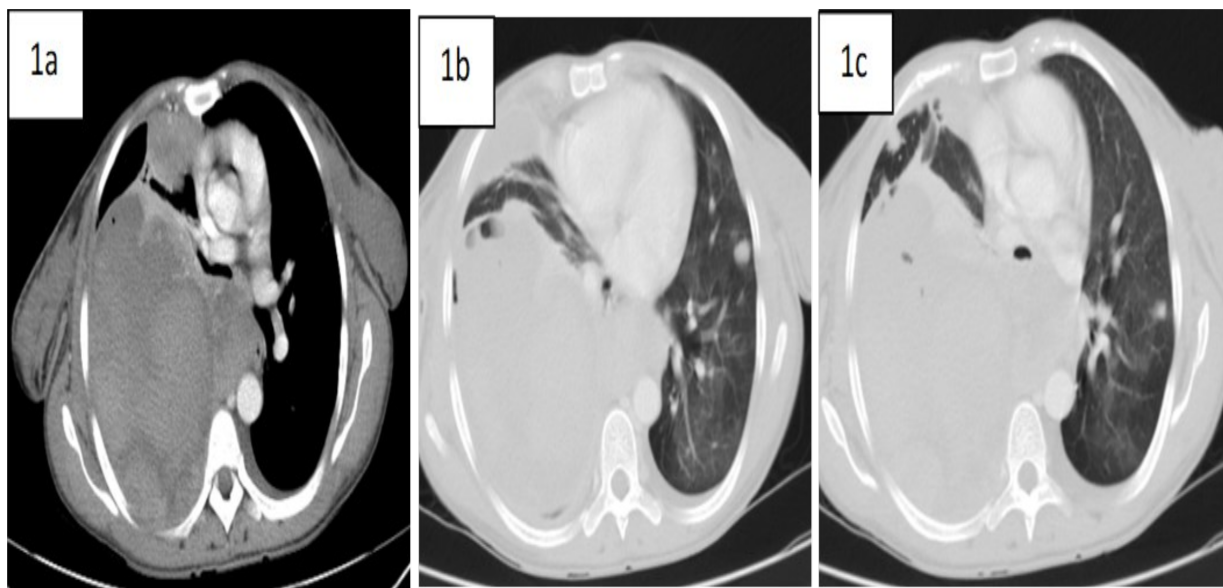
1a) Post-contrast axial CT of the patient shows a heterogeneous hyper-attenuating collection in the right pleural cavity with no contrast enhancement, suggesting a massive hematoma collection that has compressed the adjacent lung parenchyma. A cannon-ball-type lung nodule is also visible in the visualized part of the right lung in a paracardiac location. Axial lung window chest CT at different levels (1b and 1c) show bilateral rounded lung nodules.
